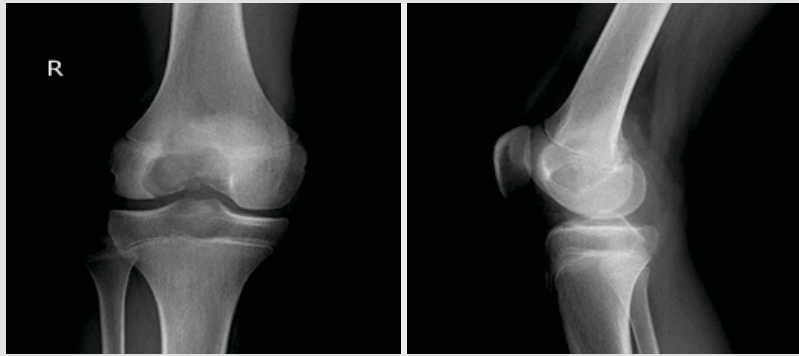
(a and b) X-ray showing radiolucent lesion over epiphysis of the distal end of femur.
